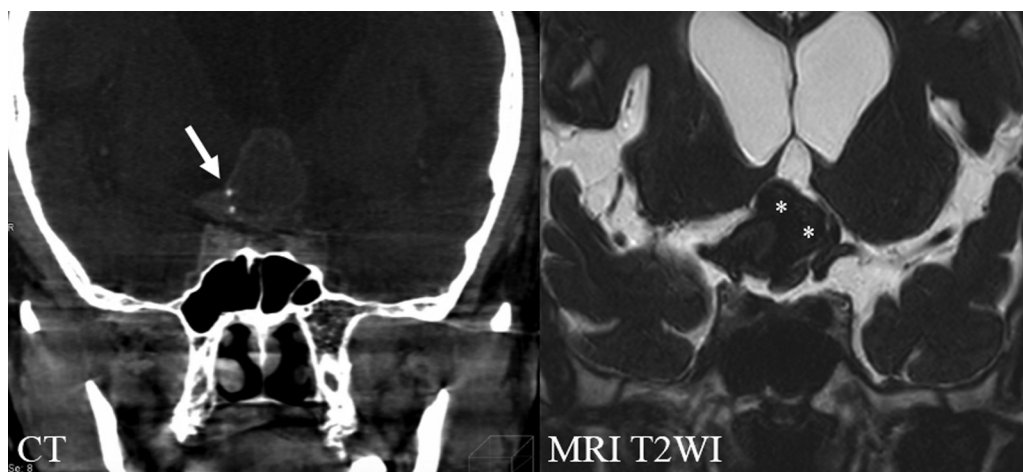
Sagittal computed tomography (CT) scans demonstrating very severe calcifications (white arrow) around the aneurysm neck. Thrombotic aneurysm (asterisks) compressed and thinned the optic nerve.
